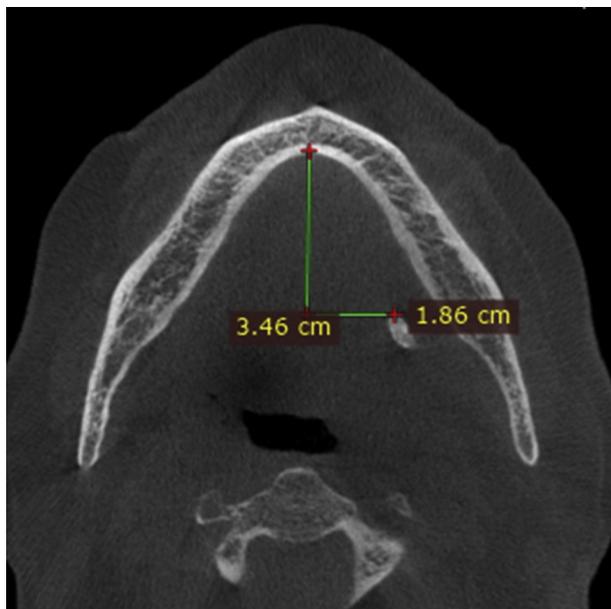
Patient 4. Cone-beam computed tomography image of a patient with left submandibular sialolithiasis showing the presence of a single calculus of relatively small dimensions located in the proximal ductal area. Transverse sectional view showing the measured distance landmarks for the approximate location of the calculus in relation to the midline, because dental landmarks were absent in the posterior mandible.
